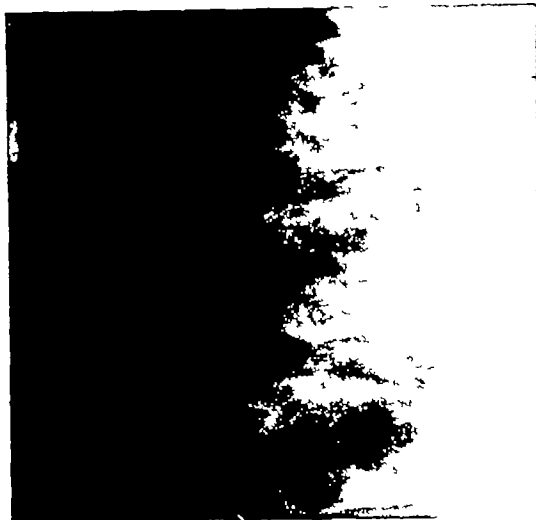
Lateral roentgenogram of the dorsal vertebræ in a boy, seven years of age showing the anterior translucent "split" as described by Köhler and Hahn. This line is absolutely different in both location and appearance from the transverse linear marks seen in lateral films of the dorsal spine in adults; the latter being due to blood vessel channels. Compare with Figures 3, 4, 5, and 6.
